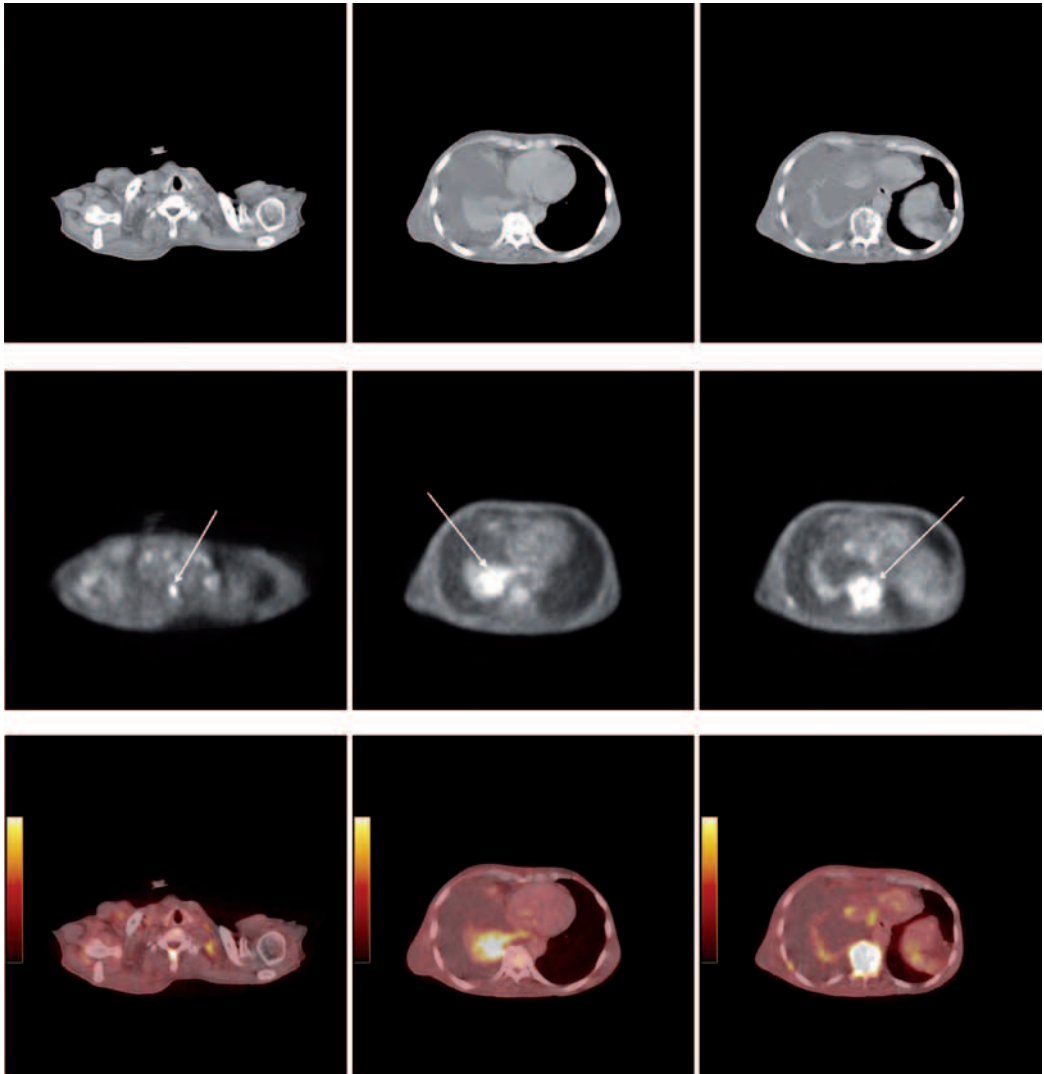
First row CT images, second row PET and the third row PET/CT fused image of a patient having Bronchogenic Carcinoma with Bone Metastases. The arrows indicate the highest activity areas.
